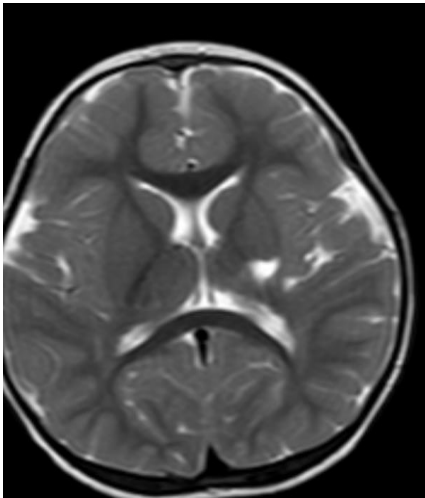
10 years old male patient with chronic interstitial nephritis for 2 years [not on dialysis] , comes to MRI unit with altered conscious level and seizures after sudden attack of high blood pressure. MRI revealed bilateral non symmetrical cortical and sub cortical abnormal high signal at T2WI and FLAIR [A-B-C-D-E] seen at parieto-occipital region with faint diffusion restriction at bilateral occipital lobes in DWI [F] suggesting posterior
